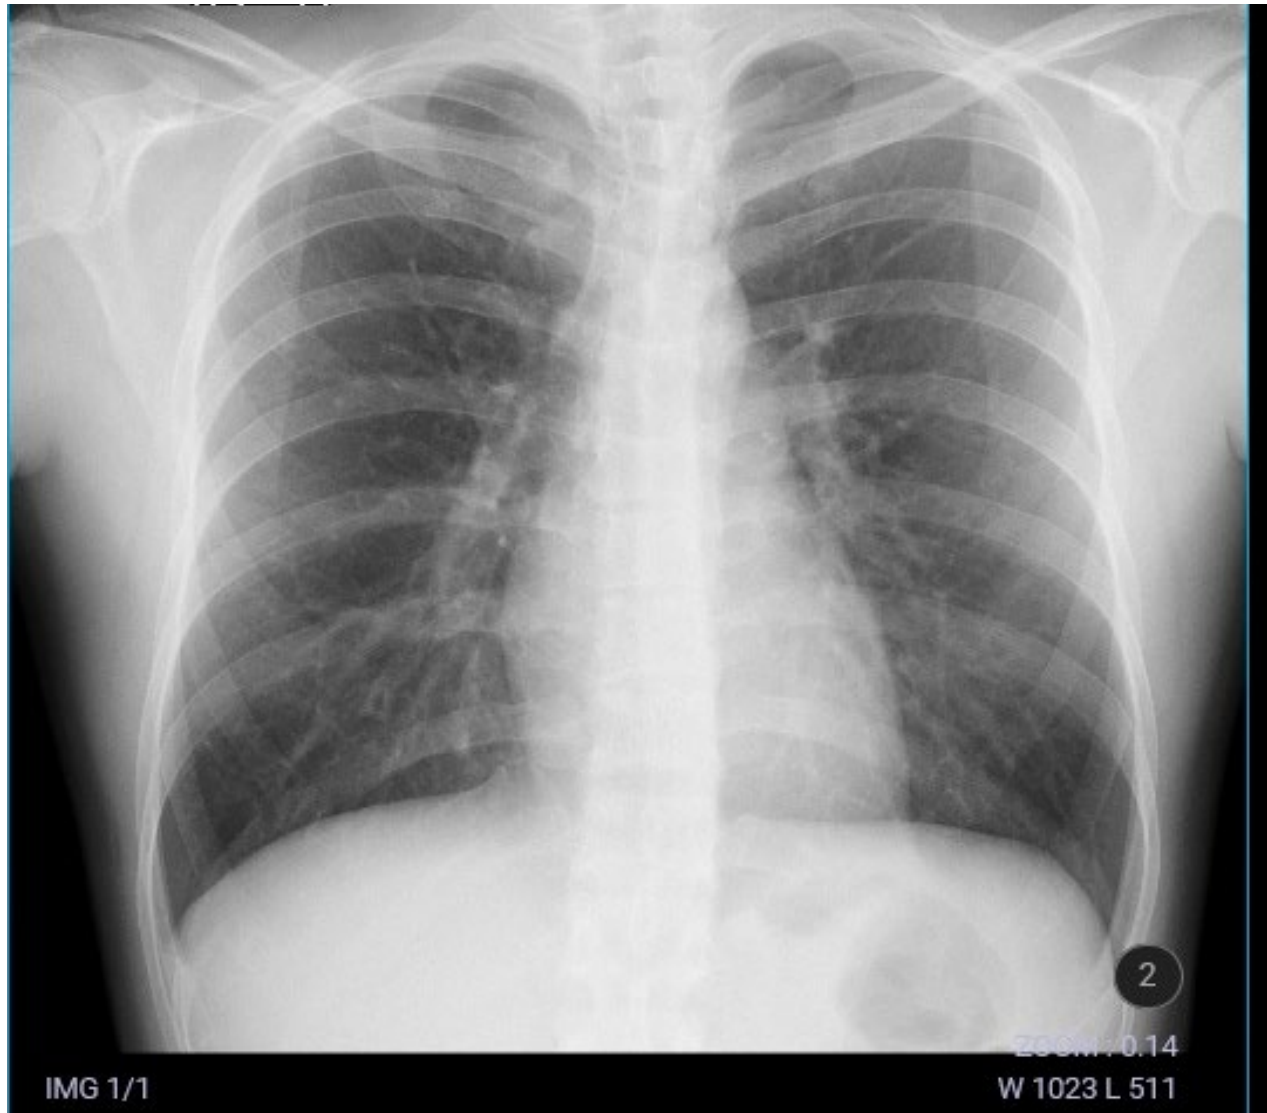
Thorax Radiography (PA)
